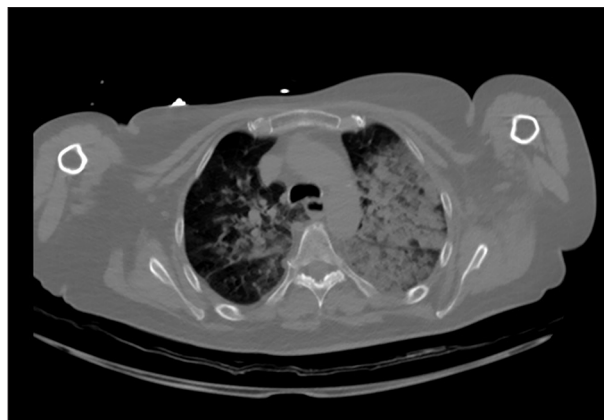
Computed tomography scan on admission. Diffuse patchy alveolar infiltrates with a predominance to the left upper lobe.
